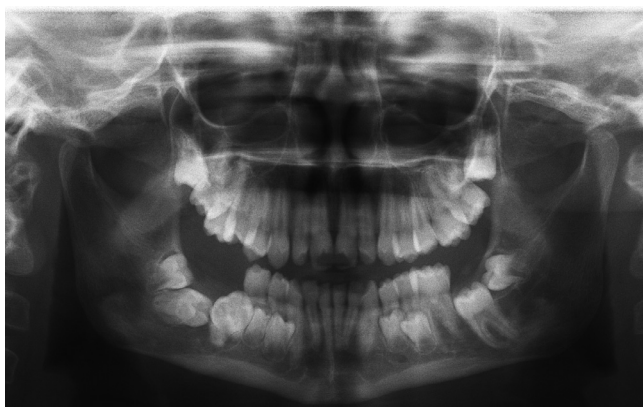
Panoramic x-ray: impacted teeth (37, 46, and 47). In the picture, there are also persistent deciduous teeth (74, 84, 75, and 85) and visible talon cusps of 13-23.
